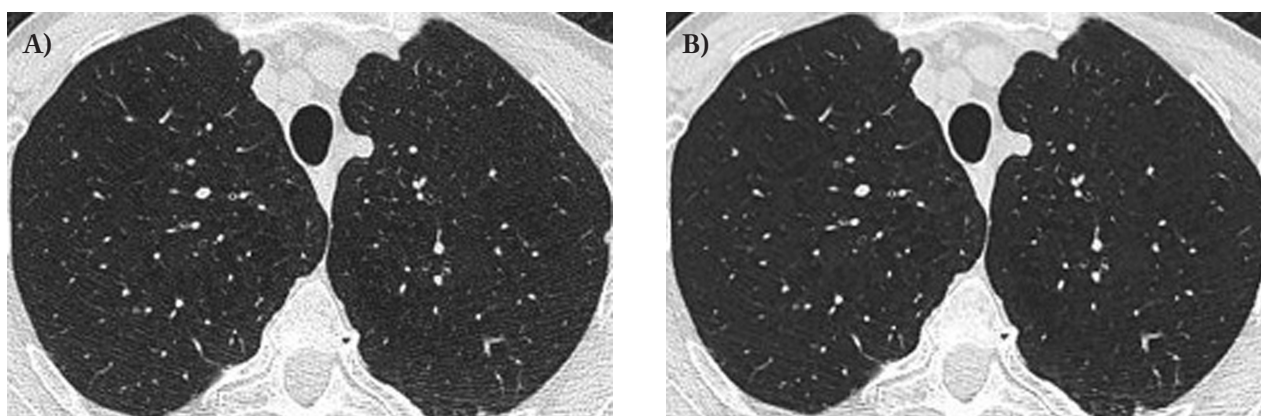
Centrilobular emphysema in transverse CT image reconstructed with A: filtered back projection and B: SAFIRE 4
